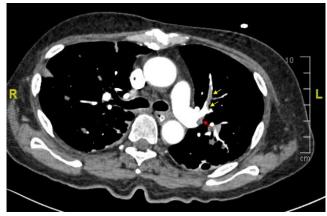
Computed tomography pulmonary angiography demonstrating filling defects along left main pulmonary artery trunk (red arrow) and left ascending pulmonary artery (yellow arrows) due to pulmonary embolism
